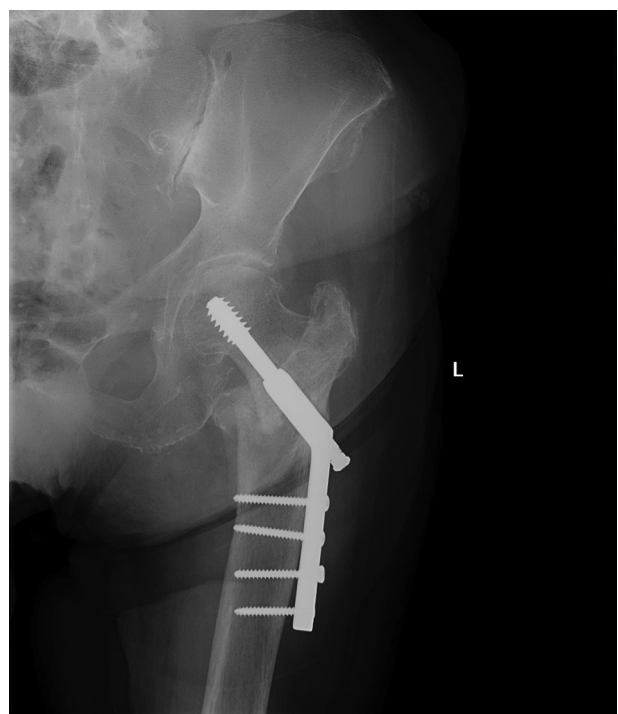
X-ray showing fracture collapse in 4-hole DHS system (from author's personal archive)
